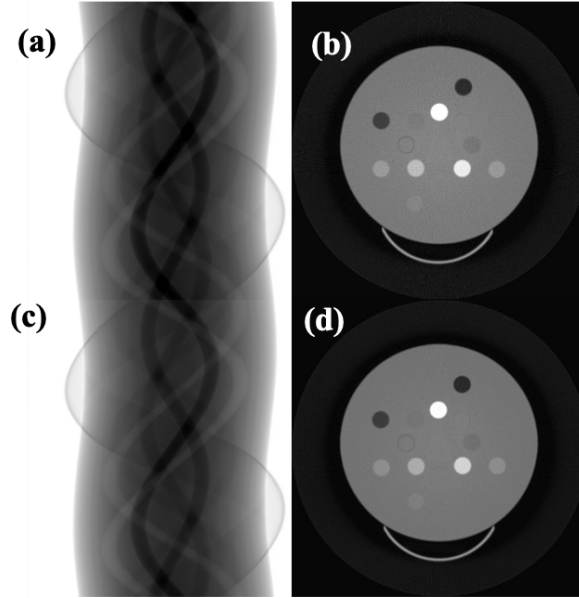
Sinogram acquired in Activion16 ((a) 100 kVp and (c) 120 kVp) and the corresponding CT image ((b) 100 kVp and (d) 120 kVp).
